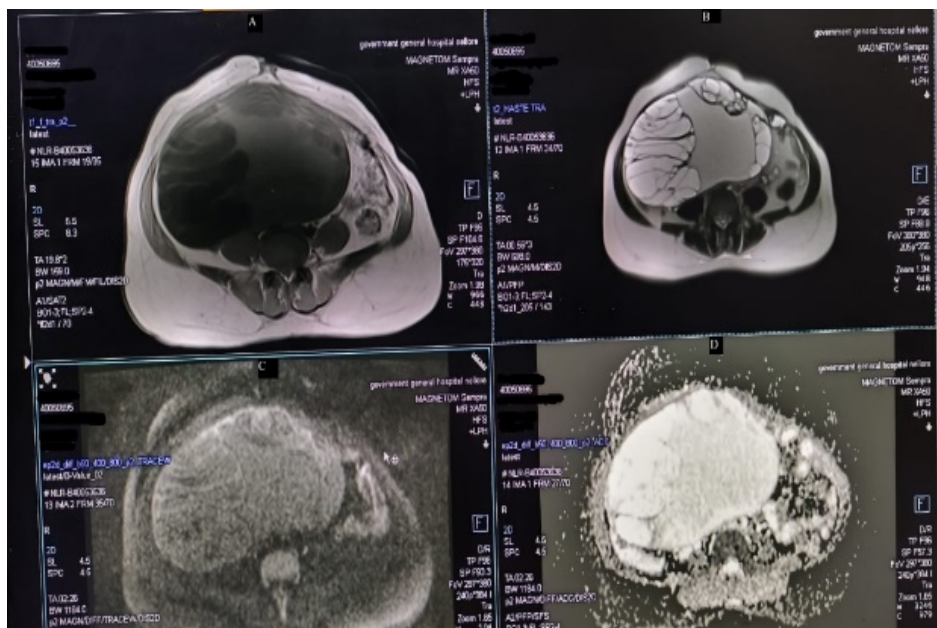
A. Axial T1 weighted image of MRI pelvis predominantly hypointense lesion with intermediate intensity areas within with hypointense thin septations. B. Axial T2 weighted image showing well defined multiloculated predominant hyperintense lesion with central intermediate intensity areas with thin hypointense internal septations. C. DWI image at b1000 showing no true Restricted diffusion. D. ADC image showing facilitated diffusion
